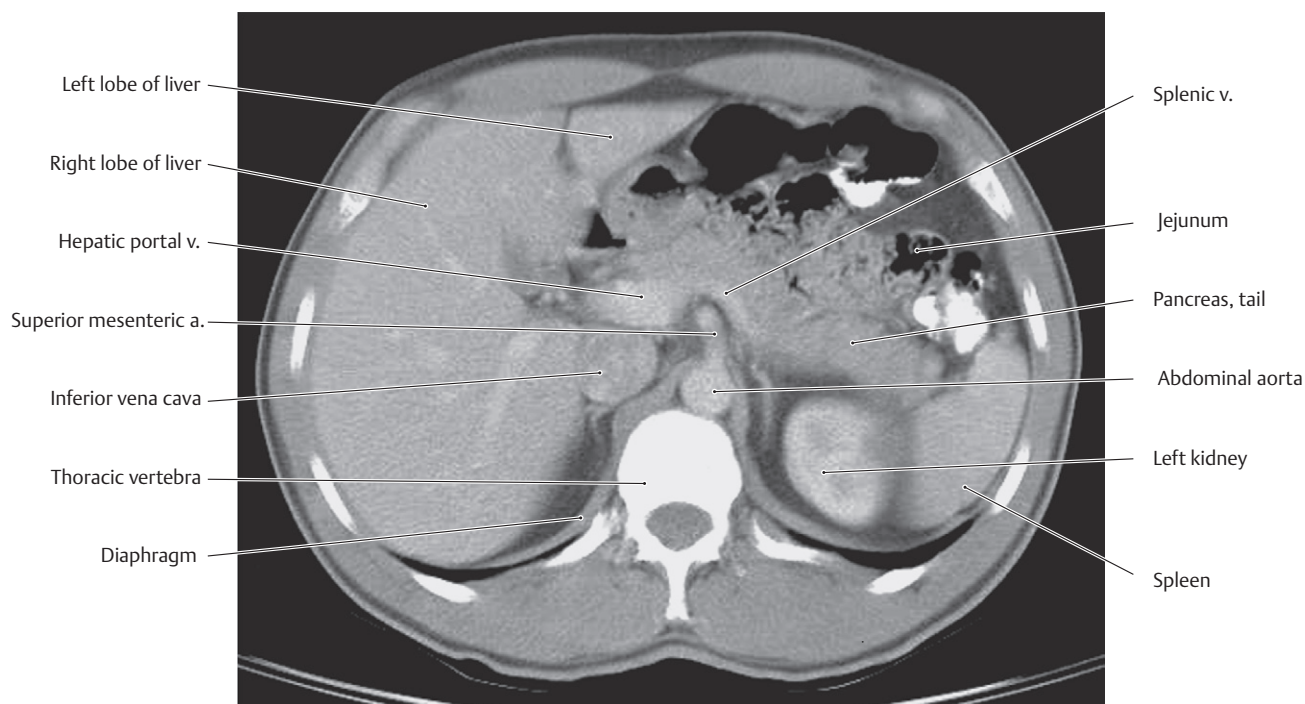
CT of the abdomen at the level of the upper kidneys
